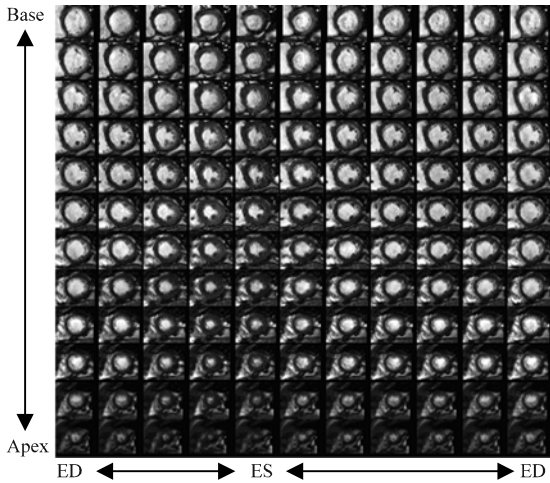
The cardiac MRI data of the patient. The horizontal line consists of frames 1, 3, 5, 7, 9, 11, 13, 15, 17, 19 and 21 of each slice and 12 slices for the vertical line, base to apex
